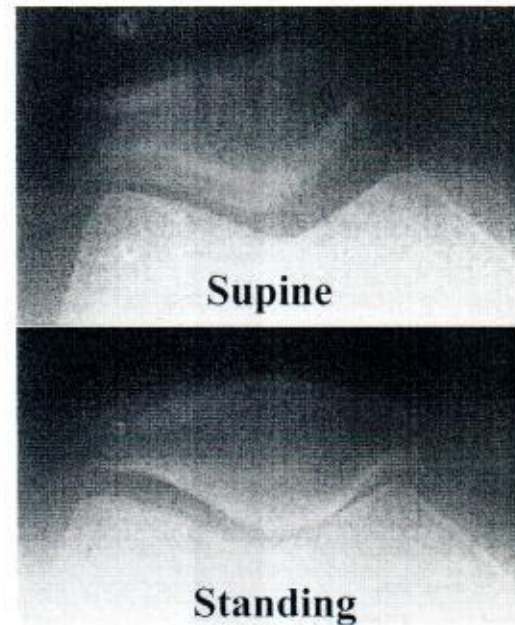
Axial radiographic views obtained in the supine and standing positions in a female with medial femorotibial arthrosis. Stage 2.0 arthrosis in the medial joint space was visualized in the standing position only
